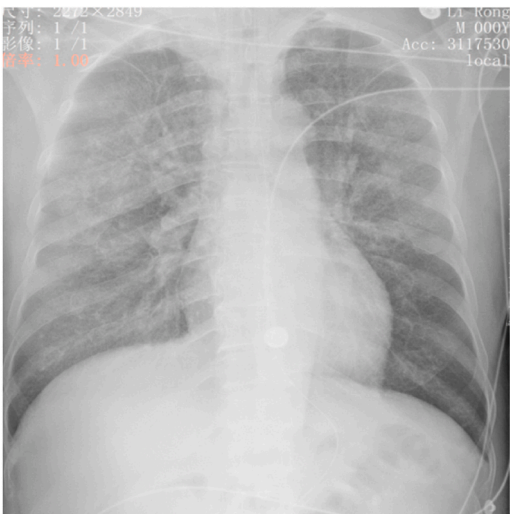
Chest X-ray captured on the tenth day of admission.
